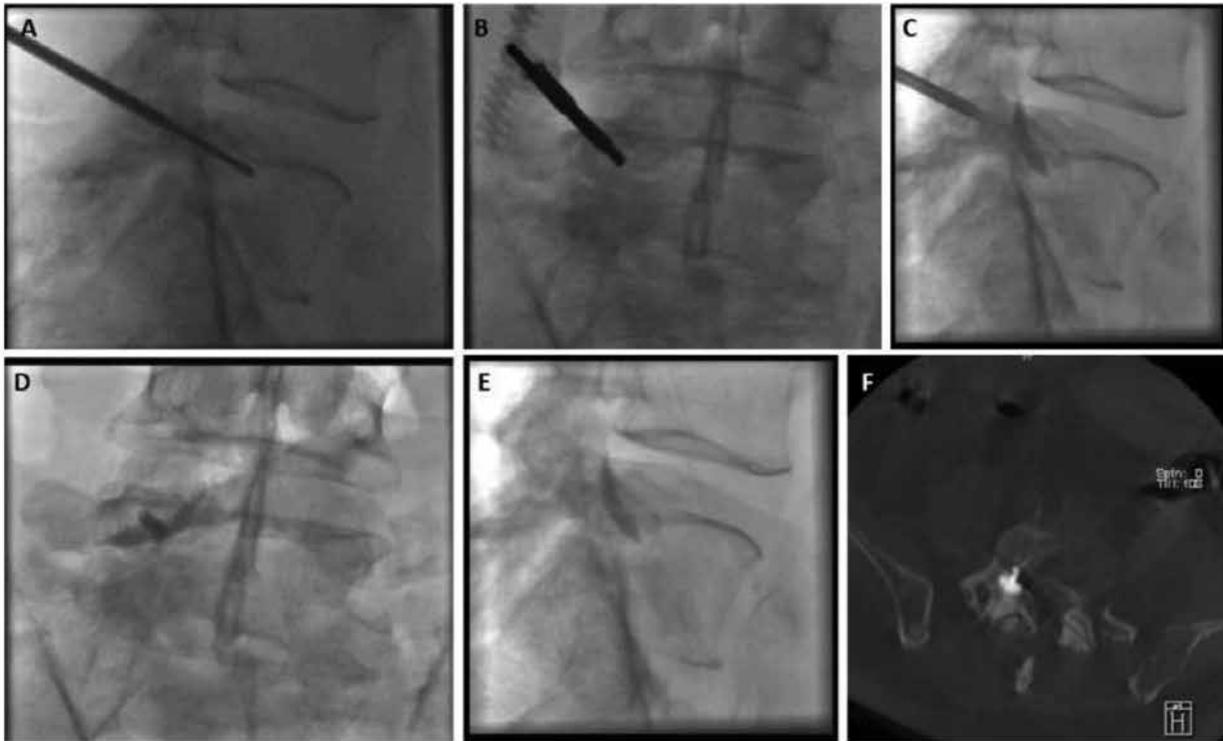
Intraoperative imaging. The procedure was performed under continuous AP and lateral fluoroscopic guidance. The fracture line in the posterior aspect of the vertebral body was cemented first, and the oblique fracture line in the pedicle was filled as the needle was withdrawn. A cone beam CT scan was used to verify cement placement. A) sagittal fluoroscopy image showing needle placement, B) AP fluoroscopy image showing needle placement, C) sagittal fluoroscopy image showing cement administration, D) AP fluoroscopy image after cement deposition, E) sagittal fluoroscopy image after cement deposition; F) axial reconstructed cone beam CT image showing extent of cement deposition.
